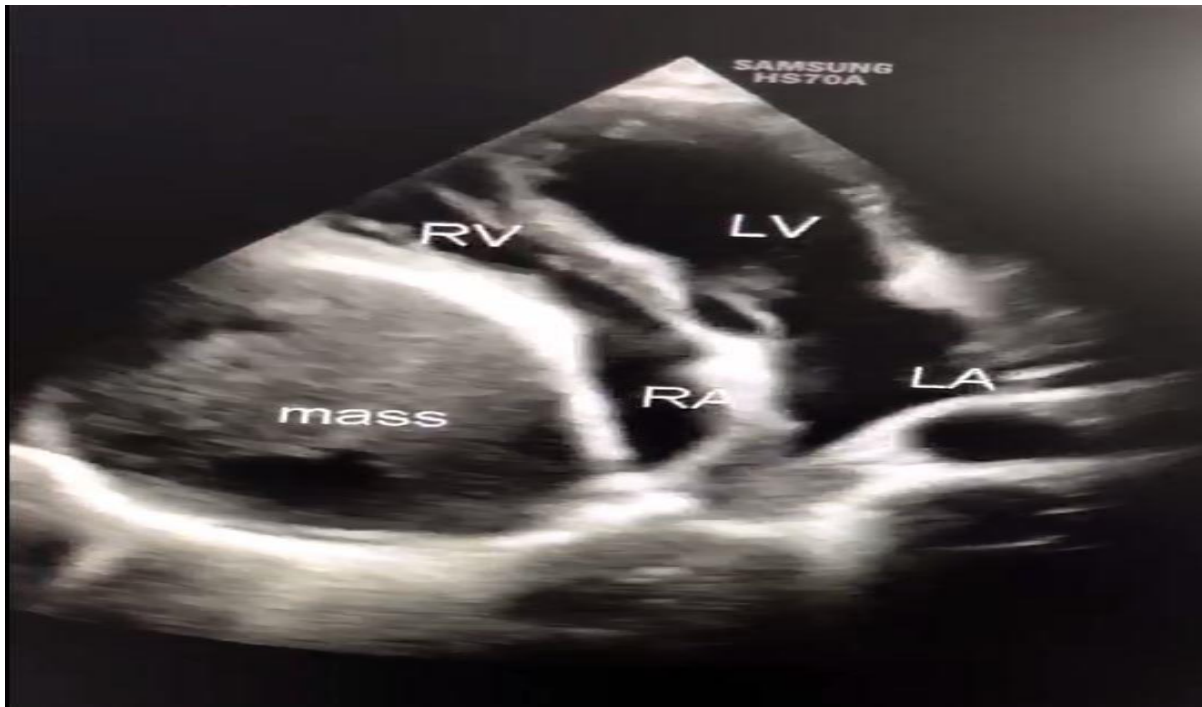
The apical 4-chamber view of transthoracic echocardiography reveals a supradiaphragmatic right paracardiac huge mass with compressive effects on the right side of the heart.
